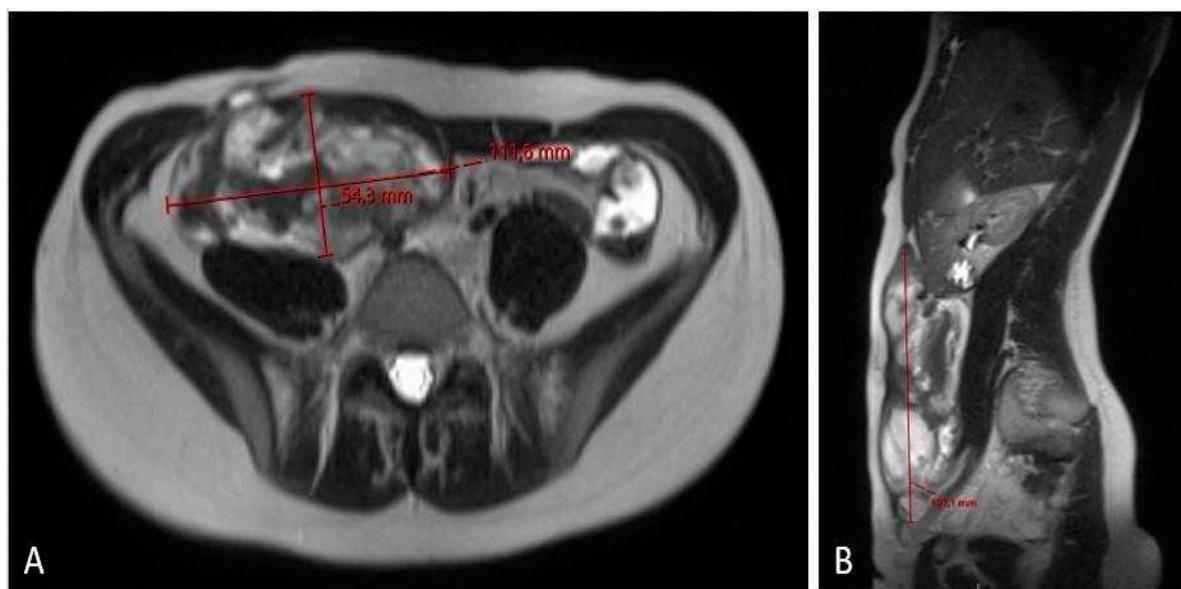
MRI scan (A – axial plane; B – sagittal plane) after 6 cycles chemotherapy showing partial regression of the tumor, now sized 11.2 x 5.4 x 19.1 cm.
